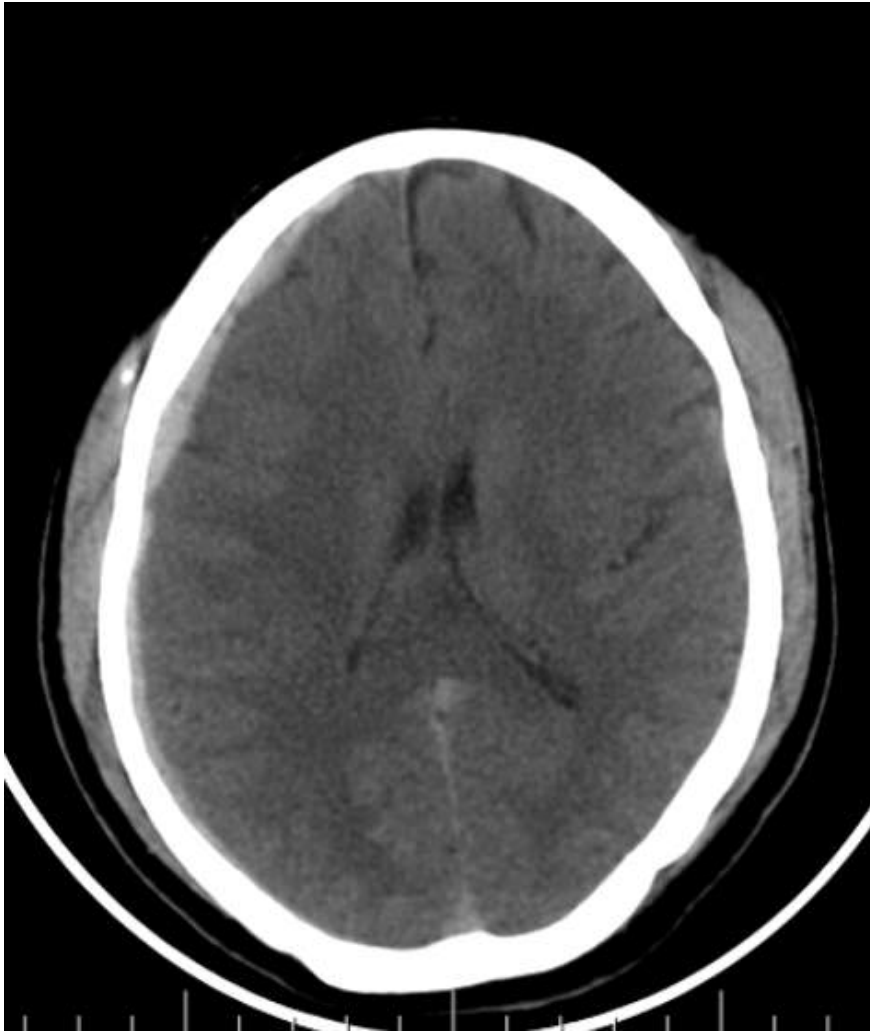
CT demonstrating right front-temporo-parietal convex hyperdense subdural hemorrhage. Case courtesy of Aditya Shetty, Radiopaedia.org, rID: 27889
